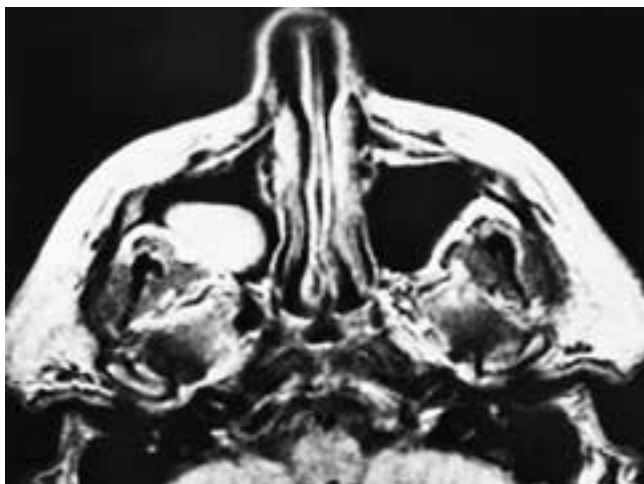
Axial proton density MR image shows a solitary retention cyst or polyp with a typically high signal intensity in the right antrum.
